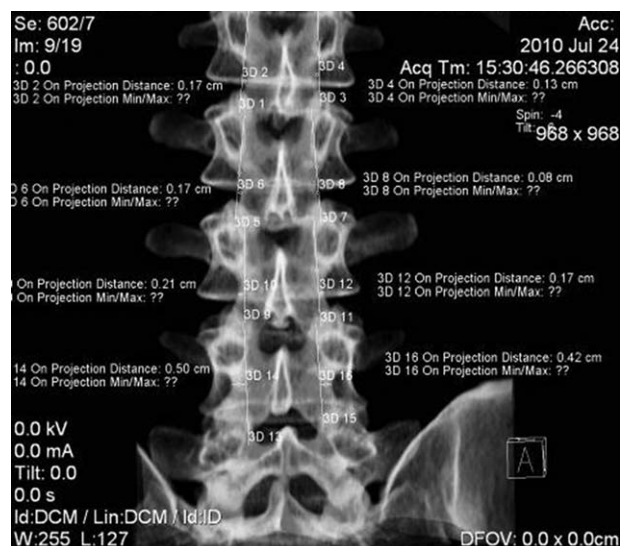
Range needed to be resected from L1 to S1 during the TFF approach measured by 3D CT images. TFF = transforaminal fenestration.
